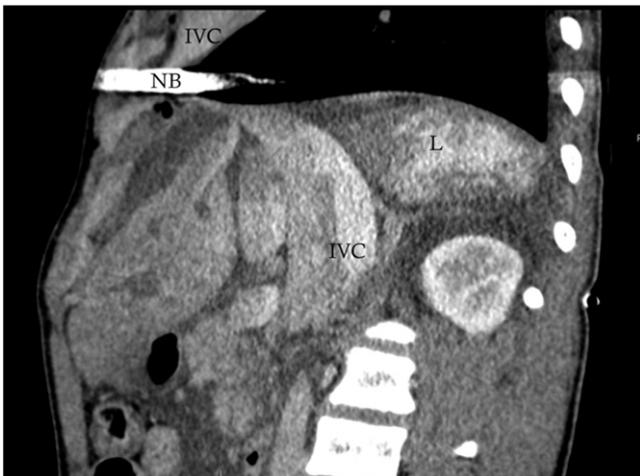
Immediate postoperative contrast-enhanced CT. Double-oblique sagittal multiplanar reconstruction showing the distortion effect of the inferior vena cava (IVC) centered on Nuss bar artifacts (NB). Venous congestion of the liver (L) can be observed.
